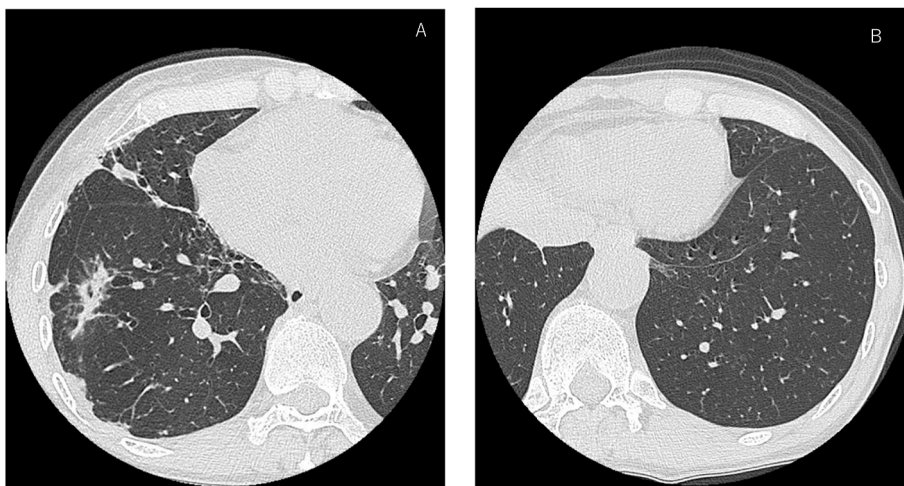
Chest CT after 24 months of treatment shows that the fibrocavitary disease and nodules had improved following treatment with clarithromycin, rifampicin, and ethambutol.
